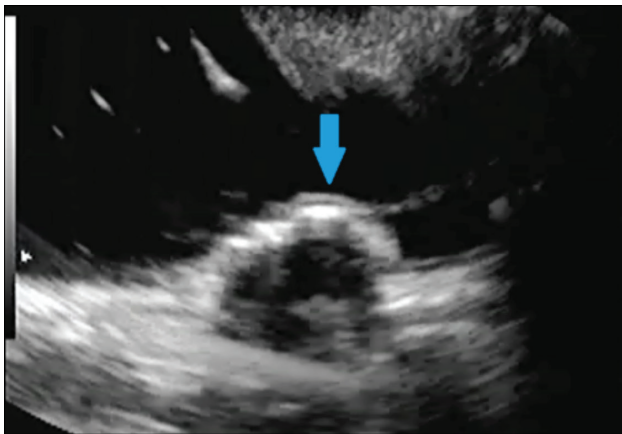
Endoscopic ultrasound image – hypoechoic nodule with a linear hyperechoic image in its interior (blue arrow).
